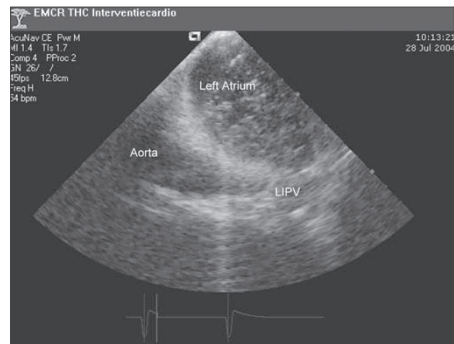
Phased-array intracardiac echocardiogram: microbubble formation during ablation, caused by overheating of the tissue, showing a 'brisk shower' and ablation is stopped immediately.
